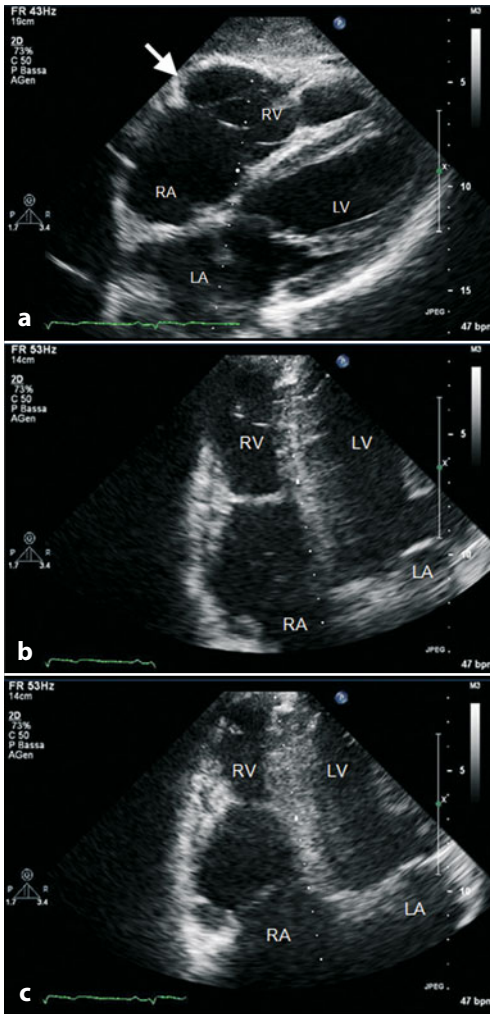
Two-dimensional echocardiogram in a patient with familial arrhythmogenic right ventricular cardiomyopathy. The disease is localized in the right ventricle. a Subcostal four-chamber view, end-diastolic frame. A wall aneurysm is evident in a subtricuspid area (*arrow*). b,c Apical four-chamber end-diastolic and end-systolic frames, respectively. A severe right ventricular dysfunction is evident (fractional area contraction of RV: 22%). LA, left atrium, LV, left ventricle, RA, right atrium, RV, right ventricle
